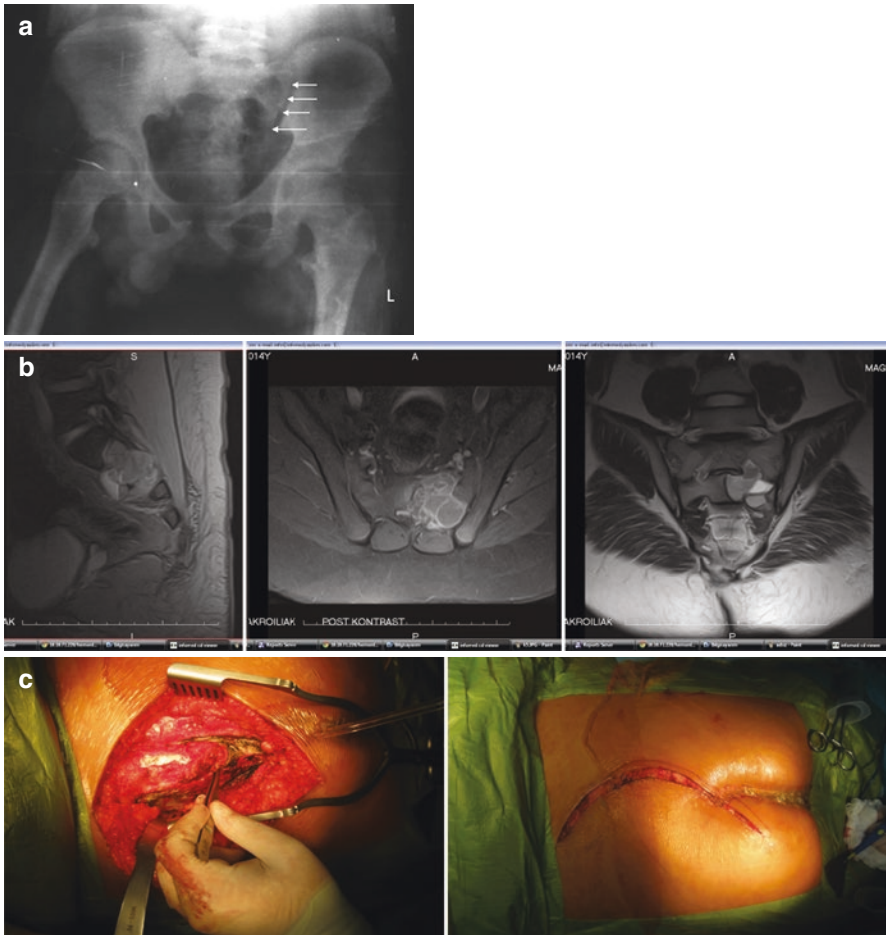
ABC of left S1–S2 (a) in a 14-year-old boy. T2-weighted and post-contrast MRI images (b) reveal multiple cysts with fluid-fluid image at left S1 and S2 growing ventrally and dorsally. Partial sacrectomy with sacral canal decompression followed by autogenous bone grafting was performed (c)
